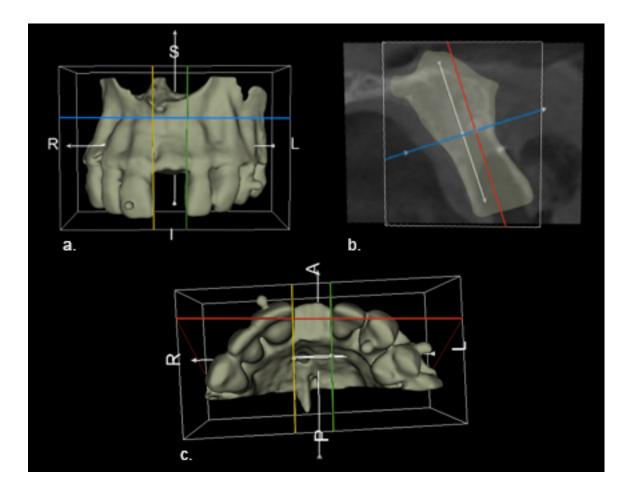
ROI definition: (a). facial view, (b). sagittal view with overlaid CBCT indicating apical extent of socket, (c). coronal view indicating position of central plane. Green and yellow planes indicate mesial and distal ROI boundaries, red indicates buccal palatal division boundary, and blue indicated apical boundary.
